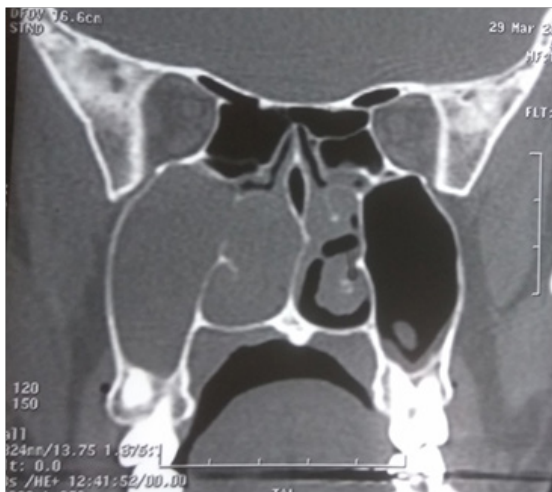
CT scan Nose and Paranasal sinus, showing an Antrochoanal polyp in right nasal cavity.
